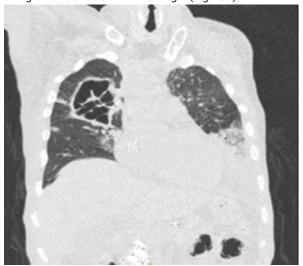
high-resolution computed tomography (HRCT) thorax showing bird's nest sign
